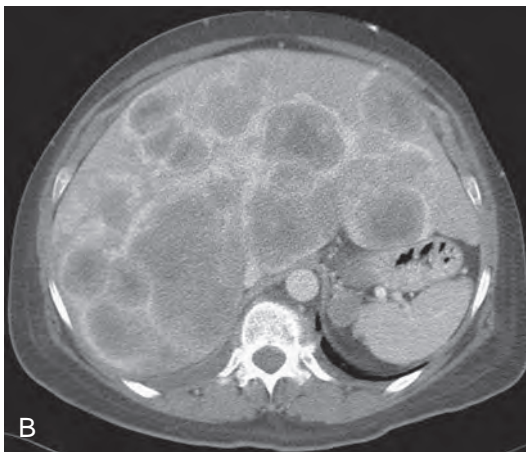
Hepatomegaly. A. Marked hepatic enlargement causes increased soft tissue density over the upper abdomen and displacement of bowel inferiorly. B. CT confirms hepatomegaly with multiple large metastases in the liver.
